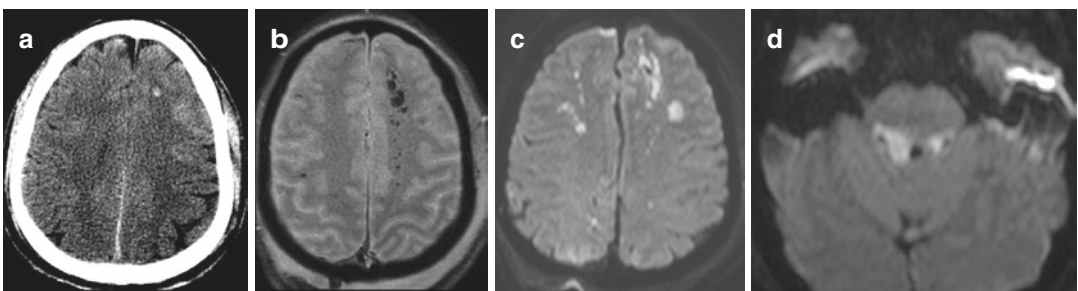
(a–d) DAI grade III. 25-year-old male with altered metal status after high-speed MCC. A mixture of hemorrhagic and nonhemorrhagic DAI in bilateral frontal lobes. CT (a) shows only one hemorrhagic lesion. Many nonhemorrhagic lesions seen on DWI (c) are not seen on
